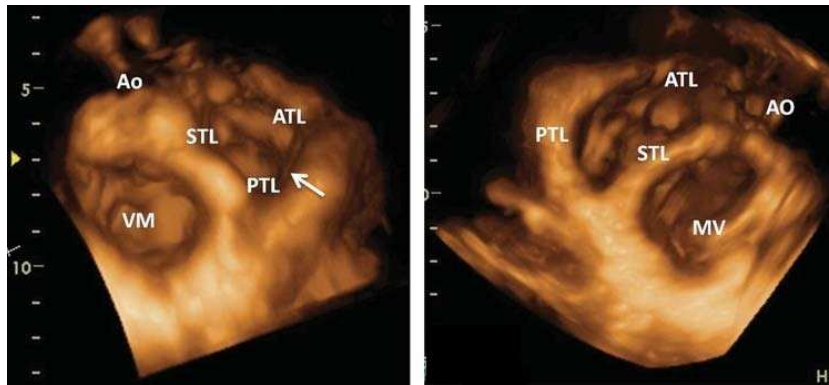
Normal TV leaflets visualized by real-time three-dimensional echocardiography from atrial (left panel) and ventricular side (right panel). ATL, anterior tricuspid leaflet; Ao, aorta; MV, mitral valve, PTL, posterior tricuspid leaflet; STL, septal tricuspid leaflet [24].
